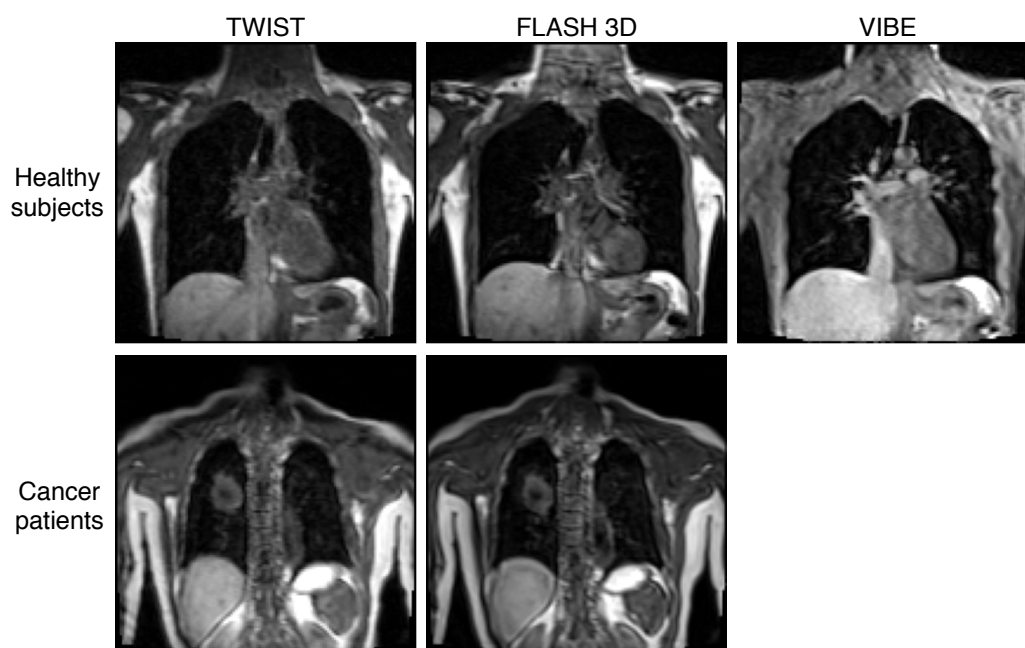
4D-MRI lung imaging of normal subject (upper row) and lung cancer patient (lower row) using three different sequences: TWIST, FLASH 3D, and VIBE. VIBE was not acquired for the patients to reduce scan time.
